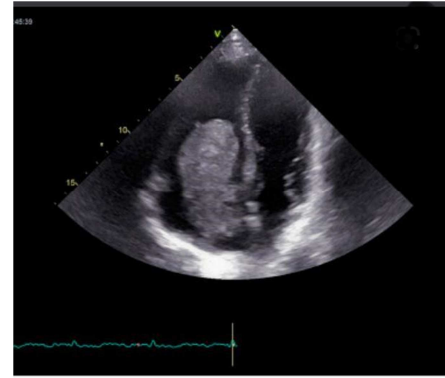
Echocardiography showed normal LV size and function, mild RV enlargement with mild systolic dysfunction, moderate RA enlargement, mobile multilobulated homogeneous large mass (45*55mm) in RA with out attachment to interatrial septum with protrude to RV in systole, moderate TR, moderate PAH, no PE, no mass in other cardiac chambers.
